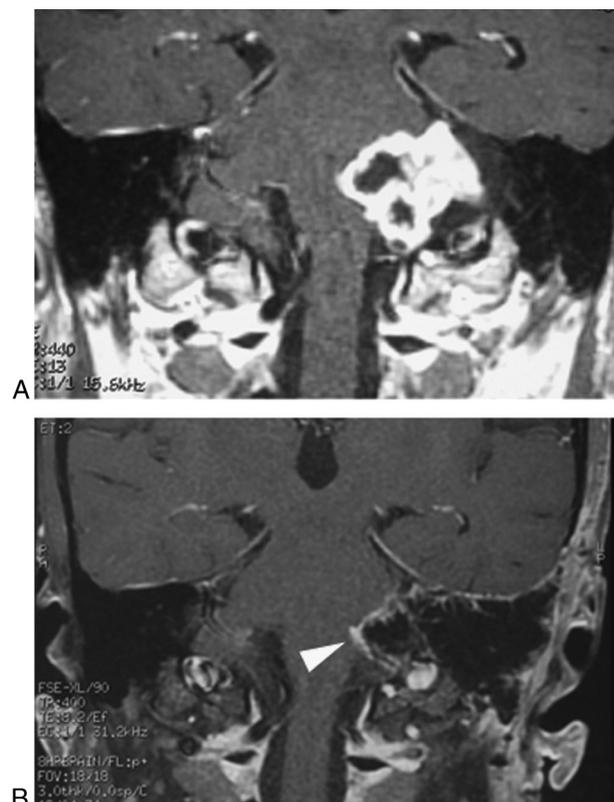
Subtotal left CVS resection example on coronal and axial MRI. *A*, Preoperative coronal T1-weighted image with contrast showing left CVS. *B*, Postoperative T1-weighted image with contrast, showing subtotal resection, left cystic tumor remnant is marked with the *white arrowhead*.
